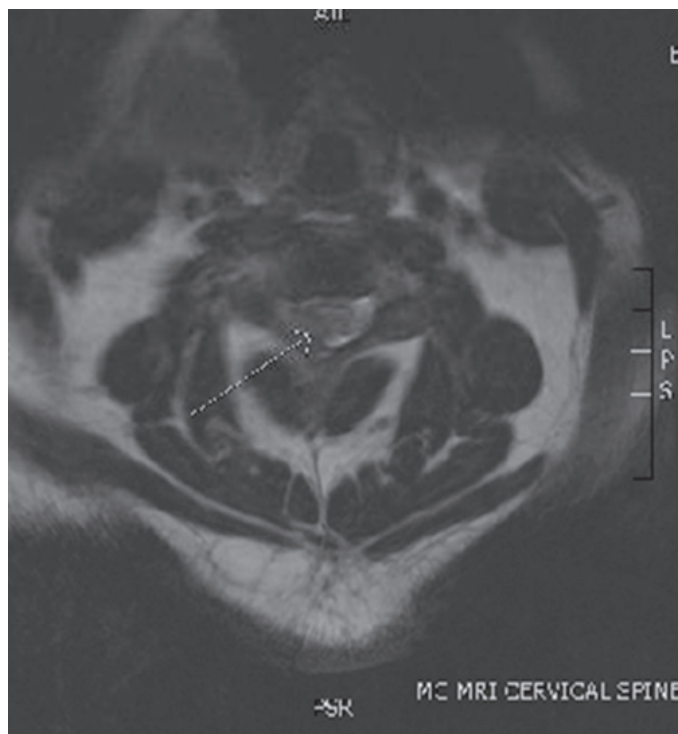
Pre-surgery axial cut MRI C-spine.
